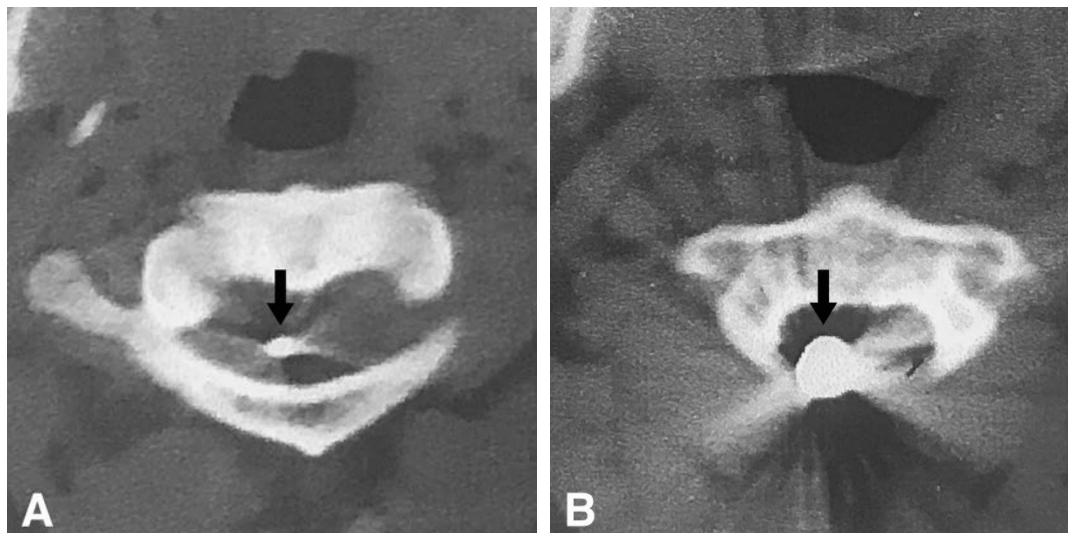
Complimentary computed tomography revealed the bullet positioning in the posterior aspect with the narrow tip at the lower edge of C1 vertebra (A) and the main bullet calibre at the C2 level (B).
